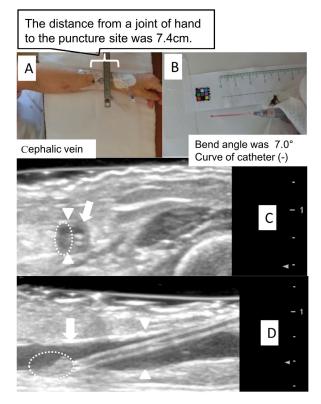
Forearm vein (non-CF): Case 20201. (A) Forearm insertion site. (B) Bend angle. (C) Ultrasound image before catheter removal (transverse image). (D) Ultrasound image (longitudinal image). Ultrasound images showing vessel wall (arrowheads), catheter tip (arrows), and thrombus (dotted circle).
